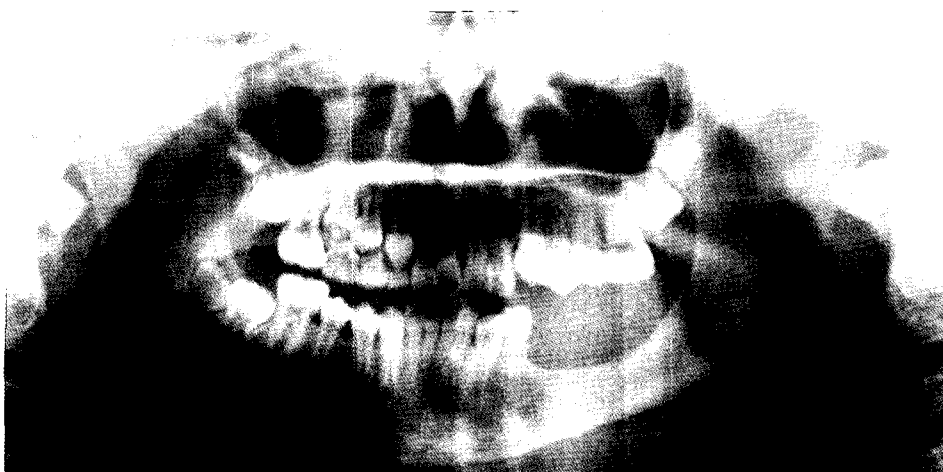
Panoramic radiograph taken eighteen months postoperatively shows no evidence of recurrence.
